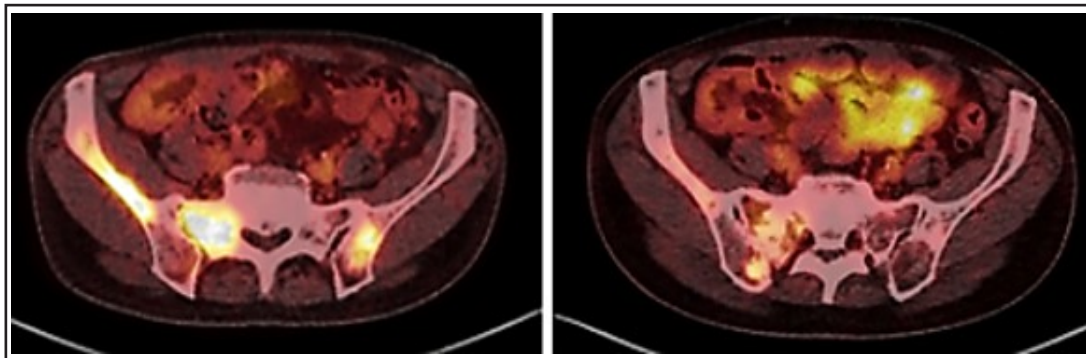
PSMA PET-CT of osseous metastases (white) before TMI treatment (left) and regression of the osseous metastases five months after the start of TMI treatment (right).
